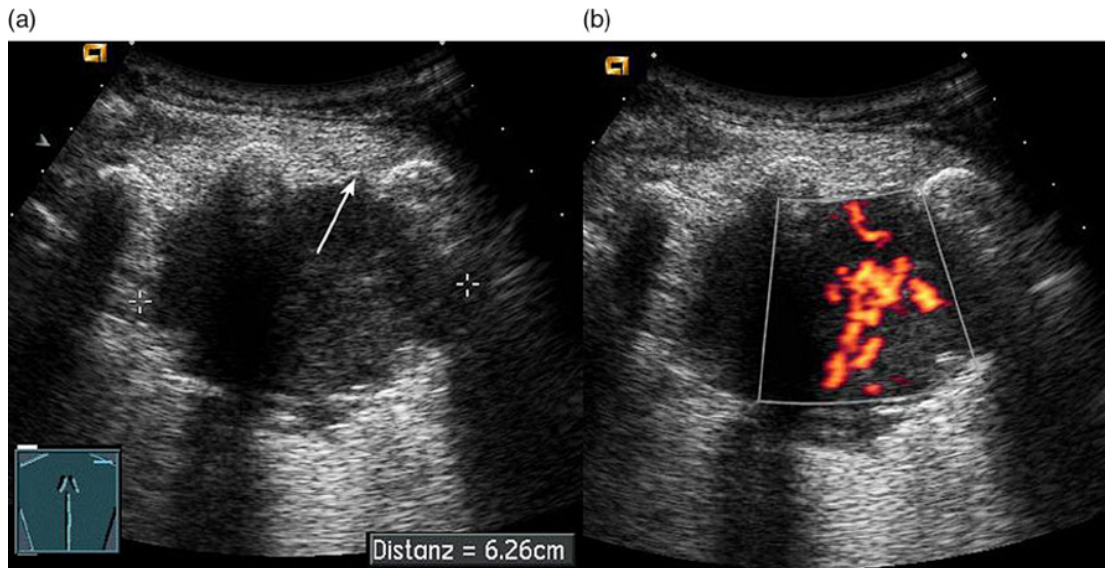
Lung cancer appears as a rounded consolidation at the site of the patient's pain. (a) The disrupted pleural line (arrow) indicates that the tumour has infiltrated the chest wall, resulting in a loss of pleural sliding. (b) The characteristically exaggerated blood flow on colour Doppler due to neovascularisation is often described as a 'vascular inferno'. An ultrasound-guided biopsy confirmed the diagnosis.
